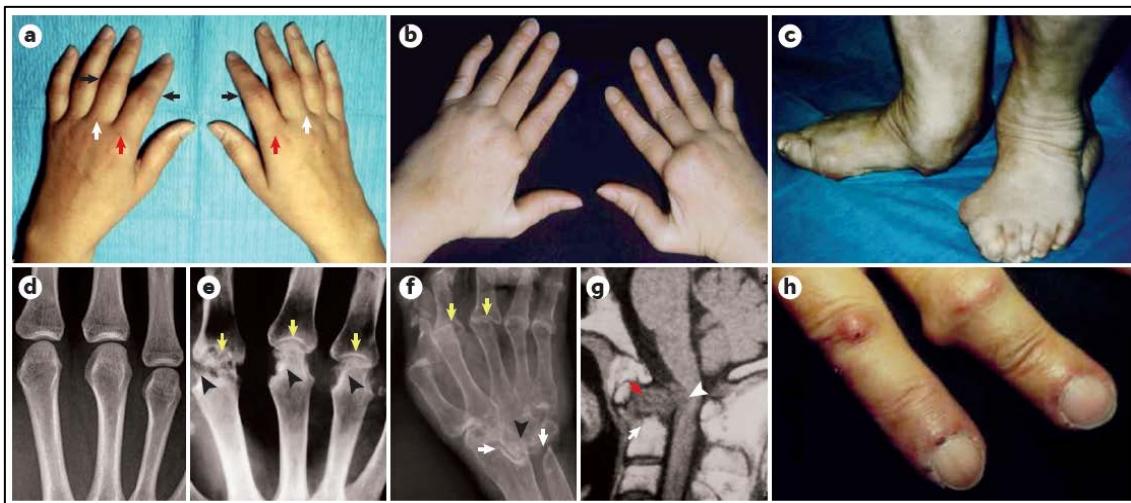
Manifestaciones clínicas de la RA. A) RA temprana caracterizada por una leve y apenas perceptible hinchazón de la segunda (flecha roja) y tercera (flecha blanca) articulación metacarpofalángica de ambas manos y de varias articulaciones interfalángicas proximales (flechas negras). B) RA establecida con varias deformidades, incluida la subluxación en las articulaciones metacarpofalángica, deformidades de cuello de cisne de varios dedos, que se observan sobre todo en el dedo meñique, y una deformidad en Z del pulgar de la mano derecha. C) RA severa de inicio tardío con afectación mutilante de las articulaciones del pie y del tobillo. D-F) Radiografías convencionales de la mano que van desde una articulación normal (D) a daños graves (E y F) con erosiones óseas (E, puntas de flechas negras) y estrechamiento del espacio articular que corresponde a la pérdida de cartílago (E, flechas amarillas) y cambios mutilantes, donde, por ejemplo, el espacio articular (cartílago) entre los diversos huesos carpianos pequeños se reduce y se fusionan (F, punta de flecha negra). Los cambios mutilantes también implican deformaciones (F, flechas amarillas) y la destrucción del radio distal y el cúbito distal donde interactúan con el carpo (F, flechas blancas). G) MRI de la región cervical de la columna que muestra una severa formación de pannus (proliferación del tejido sinovial) (flecha roja) en la articulación atlantoaxoidea con compresión de la médula (punta de flecha blanca) debido a la hiperplasia sinovial. Las cavidades muestran erosiones severas (flecha blanca). H) Presencia de nódulos reumatoideos en las caras dorsal y lateral de varios dedos y vasculitis periungual en los pliegues de las uñas (puntos negros) (Smolen et al., 2018).
